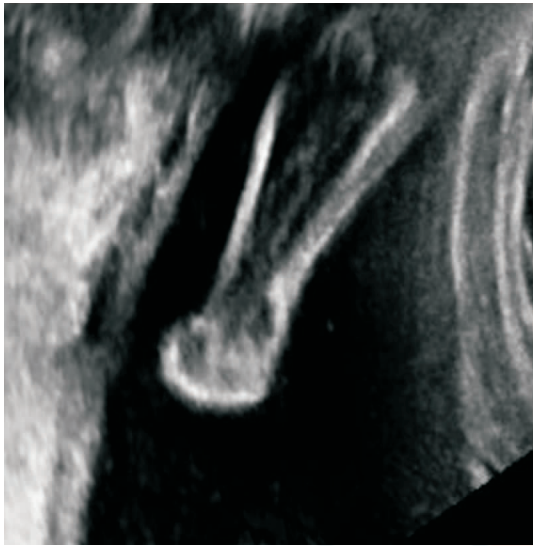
A solid mass with irregular shape, measuring 1.7 x 1.2 cm without Doppler flow, was detected in the distal end of the left lower leg
